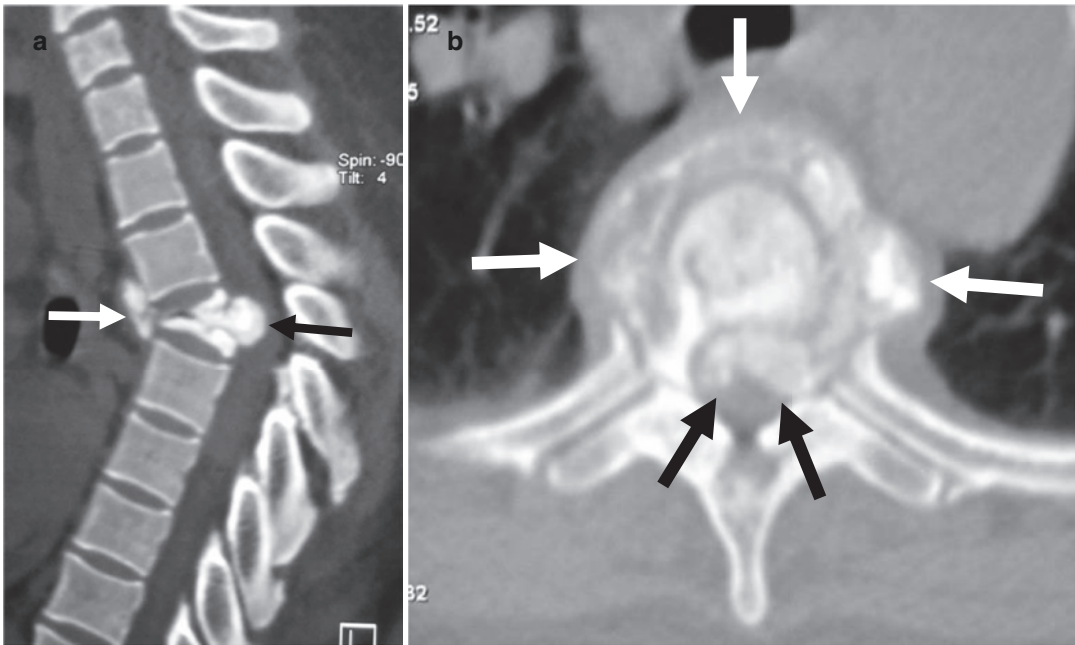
Long-standing tuberculous spondylodiscitis at T4–6 vertebral levels. (a) Sagittal and (b) axial CT images taken in bone window show disco-vertebral destruction with bone sclerosis and calcified paravertebral (white arrows) and epidural (black arrows) abscesses.
